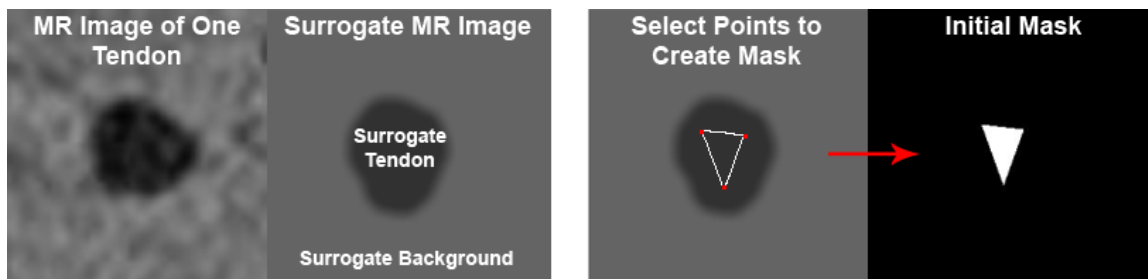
An MR image of a tendon (far left) and the surrogate MR image (middle left) from which a contour was grown. The initial mask (far right) was defined by connecting 3 user-selected points (middle right) on the tendon region of the surrogate MR image.
